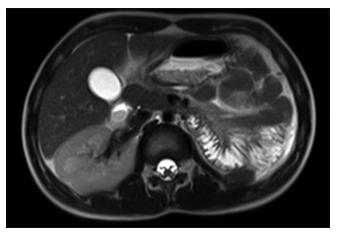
Abdominal magnetic resonance imaging. A HASTE sequence axial section shows the left renal agenesis
